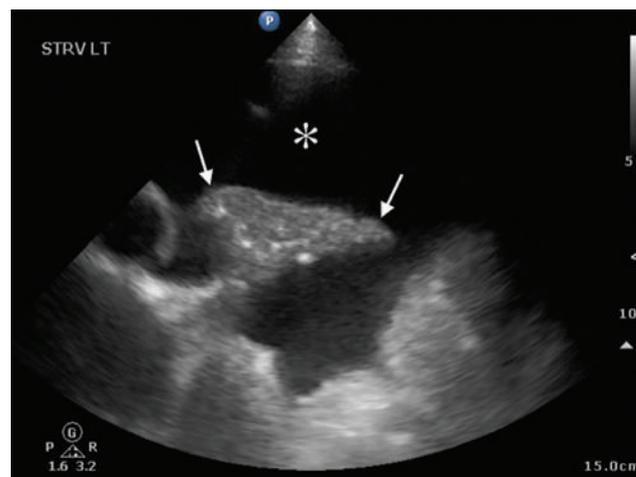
Pleural effusion. Ultrasound image demonstrates a large pleural effusion (asterisk). Adjacent to the pleural effusion is collapsed lung (arrows).
